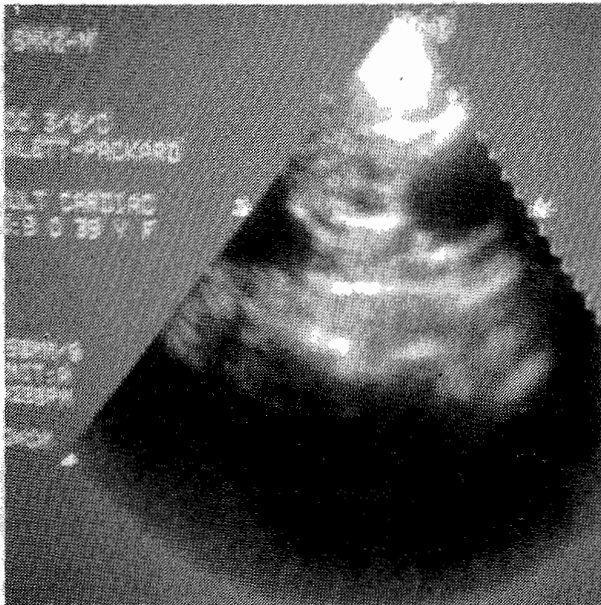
is from Case 1, B O. It is an ultrasound image of the kidney showing echoluscent shadows with rear wall enhancement in both poles; suggestive of true cysts.
